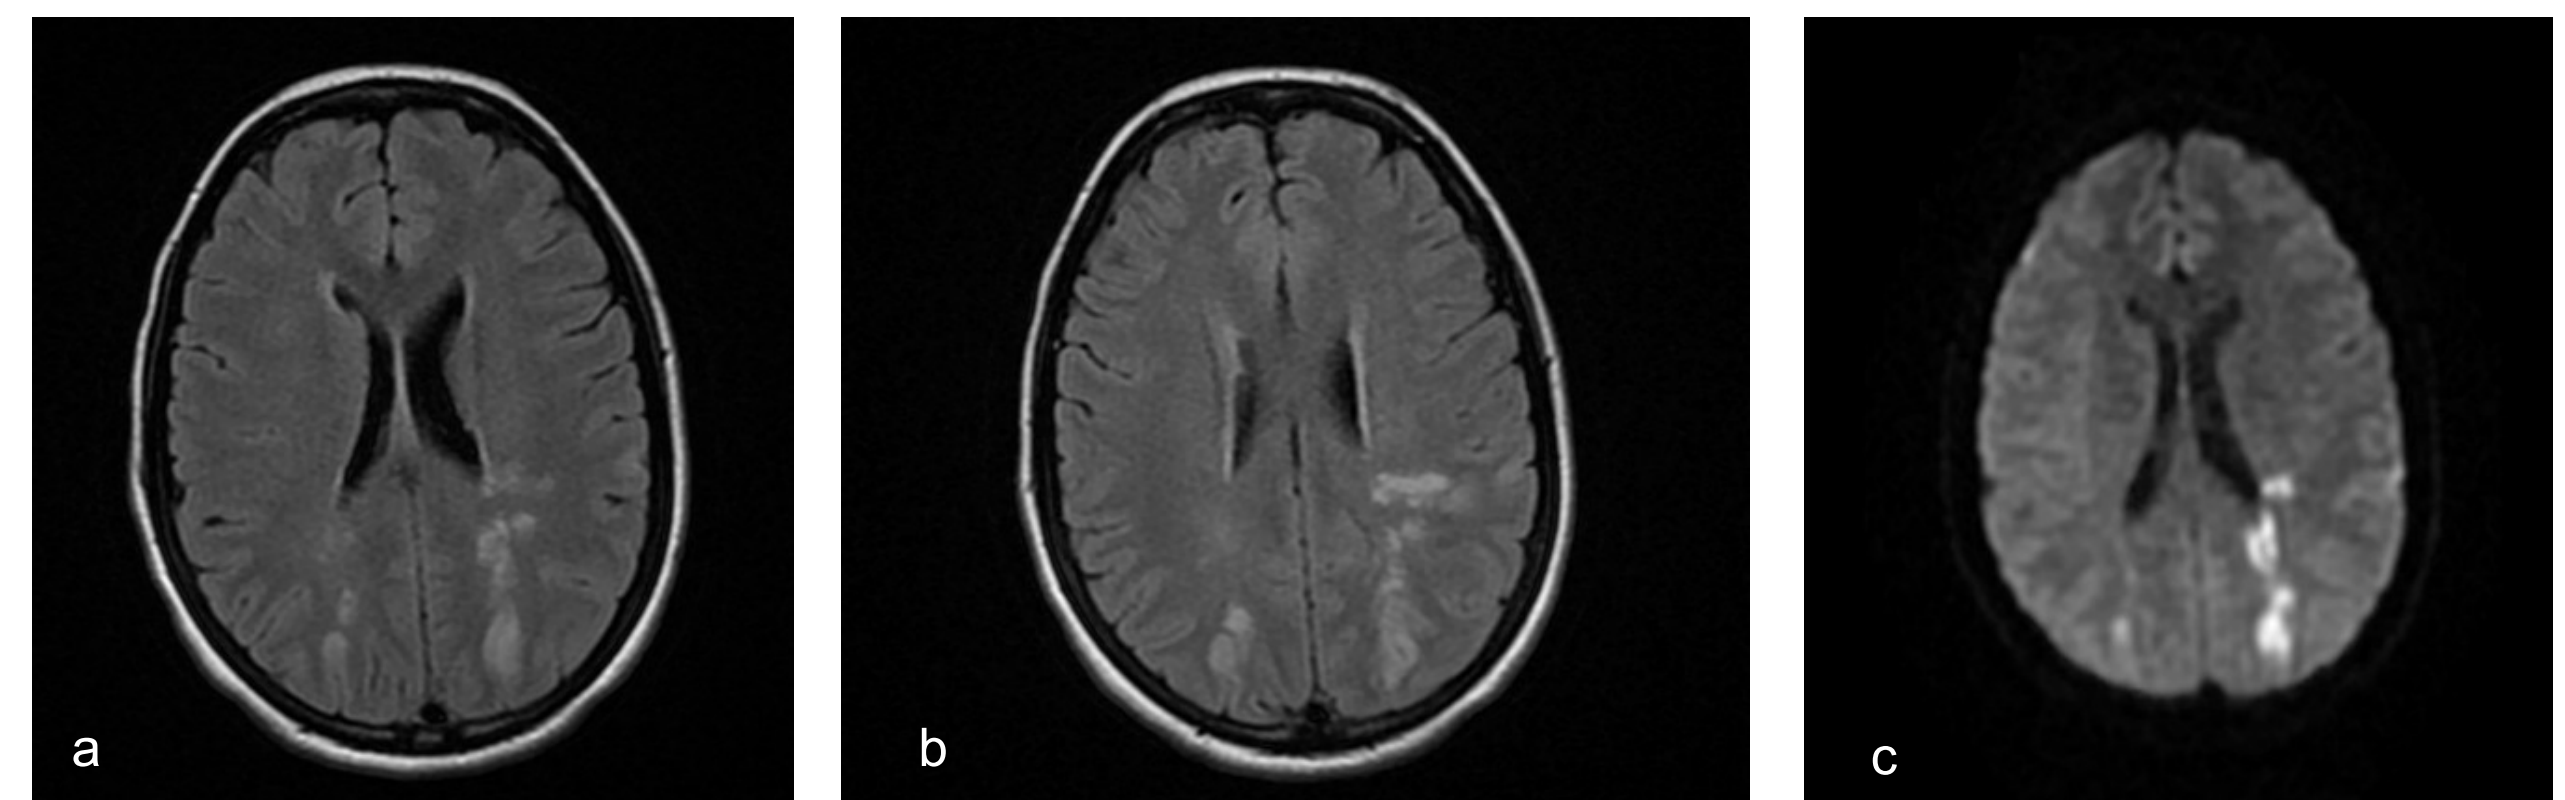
a,b,c: Axial T2 FLAIR (a,b) and DWI (c) sequences show predominant parieto-occipital pattern
